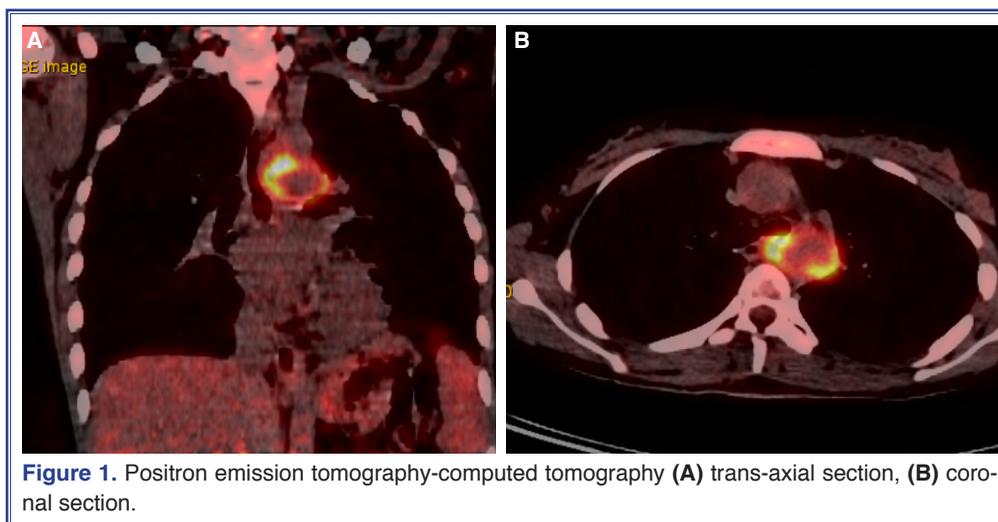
Positron emission tomography-computed tomography (A) trans-axial section, (B) coronal section.
